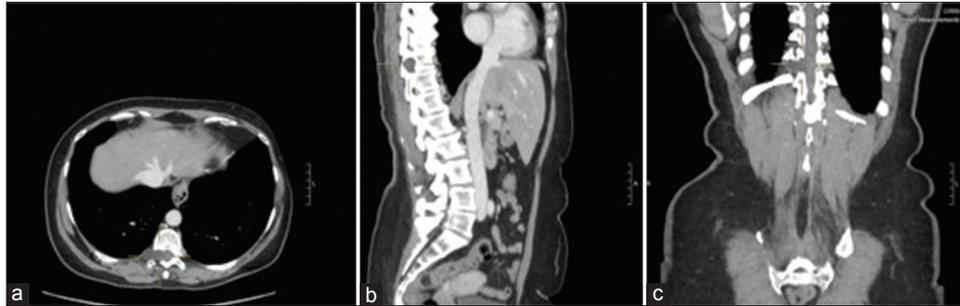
Axial (a), sagittal (b), and coronal (c) computed tomography vertebral and abdomen scans showing a hypodense “dumbbell” T10-T11 lesion of about 26 mm involving the right vertebral pedicle and the right T10 lamina.
